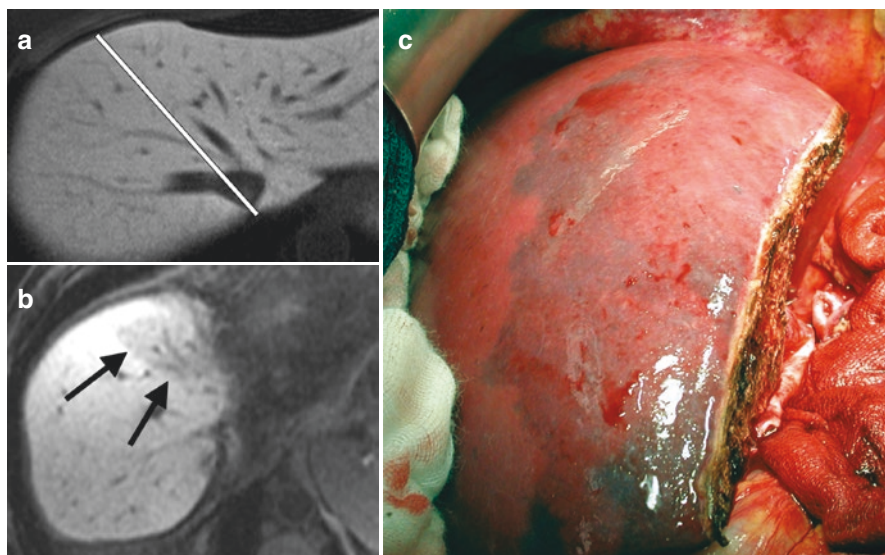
Segment VIII drainage into the MHV. (a) Axial T1-weighted preoperative image of a living donor shows a tributary vein draining segment VIII into the MHV. The hemihepatectomy plane transects this accessory vein. (b) Postoperative axial T1-weighted MR image of the recipient shows atrophy of segment VIII due to inadequate drainage. (c) Corresponding intraoperative photograph shows congestion of segment VIII. Adapted from Catalano OA, Singh AH, Uppot RN, et al. Vascular and biliary variants in the liver: implications for liver surgery. *RadioGraphics* 2008; 28:359–378
